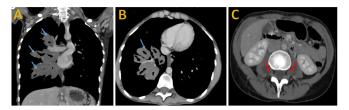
Contrast-enhanced computed tomography scan of the chest and upper abdomen—mediastinal window:(A) coronal section, (B and C) axial sections. A and B show extensive, confluent lobulated outline low- density masses (17HU) (blue arrows) extending from the carina region, right hilum and extending along the right bronchial tree encasing the pulmonary vessels, showing mild enhancement post contrast administration (40 HU)., lobulated, low-density masses (17HU) (blue arrows) extending from the carina region, right hilum, and e right bronchial tree encasin, g the pulmonary vessels, shows shwhich showhancement post conpost-contrast C) show hypo-enhancing hypo-dense masses involving the intervertebral foramen bilaterally extending medially to the psoas muscles (red arrows).
